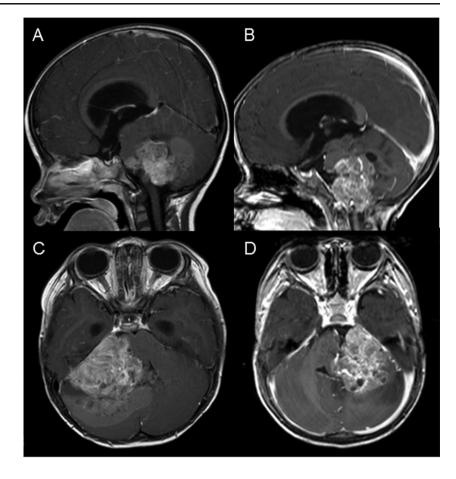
AT/RTs located in the CPA. a, b Gadolinium-enhanced T1-weighted images of a 32month-old girl. c, d Images of a 13-month-old boy. Tumors are heterogeneous and well enhanced
